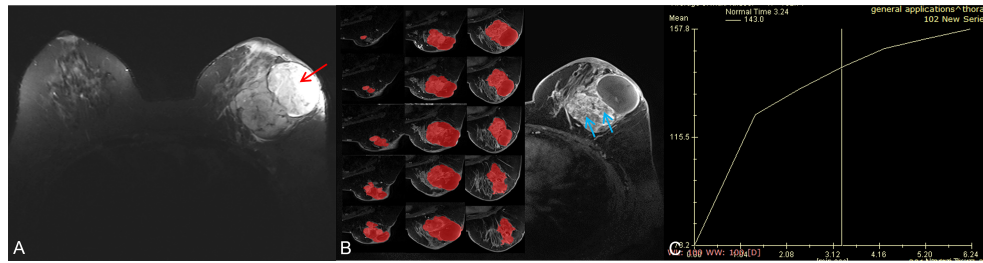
A 56-year-old woman with a borderline/malignant phyllodes tumor. (A) Axial T2WI showed a heterogeneous mass with a huge cystic cavity (red arrow) in the left breast. (B) Axial DCE-MRI showed the mass with heterogeneous enhancement and large numbers of unenhanced areas with irregular walls (blue arrow); the segmentation of VOI was shown on the left series images. (C) The time-intensity curve was type I (persistent pattern).
